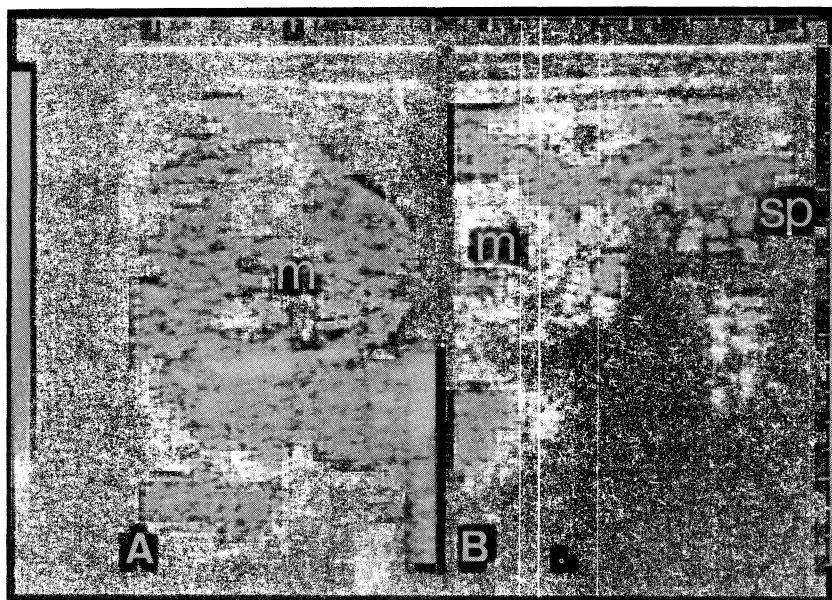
A. Antenatal sonogram showing a predominantly solid complex mass (m) with irregular cystic areas. B. Longitudinal scan showing the mass (m) attached to the fetal rump, unrelated to the fetal spine (sp).
